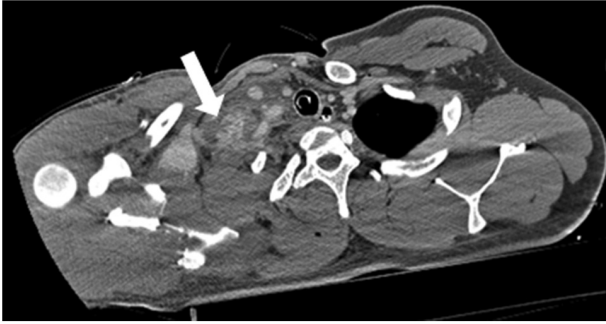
Contrast media extravasation to upper mediastinum hematoma in late phase chest CT angiography scan (white arrow).
